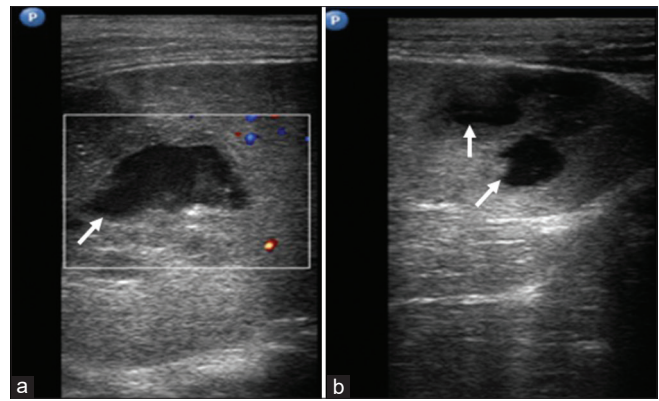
(a and b) Ultrasound of the abdomen showing multiple well-defined anechoic lesions with internal echoes within suggestive of abscesses
